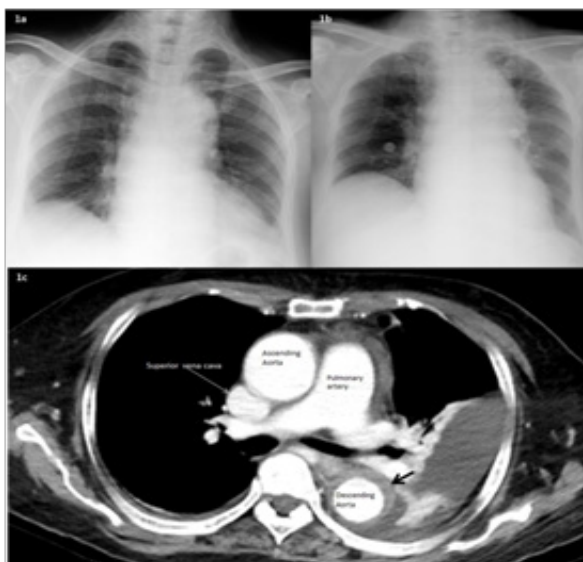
Chest X-ray (a) demonstrated tortuosity of aorta with calcification of aortic arch at admission and (b) showed progressive mediastinal widening during hospitalization. Contrast enhanced CT (c) revealed aortitis with intramural hematoma.
